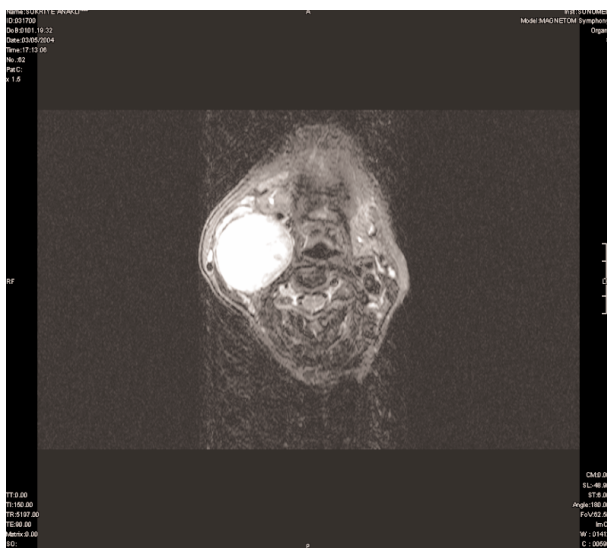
Axial magnetic resonance image of right cervical sympathetic chain schwannoma.
